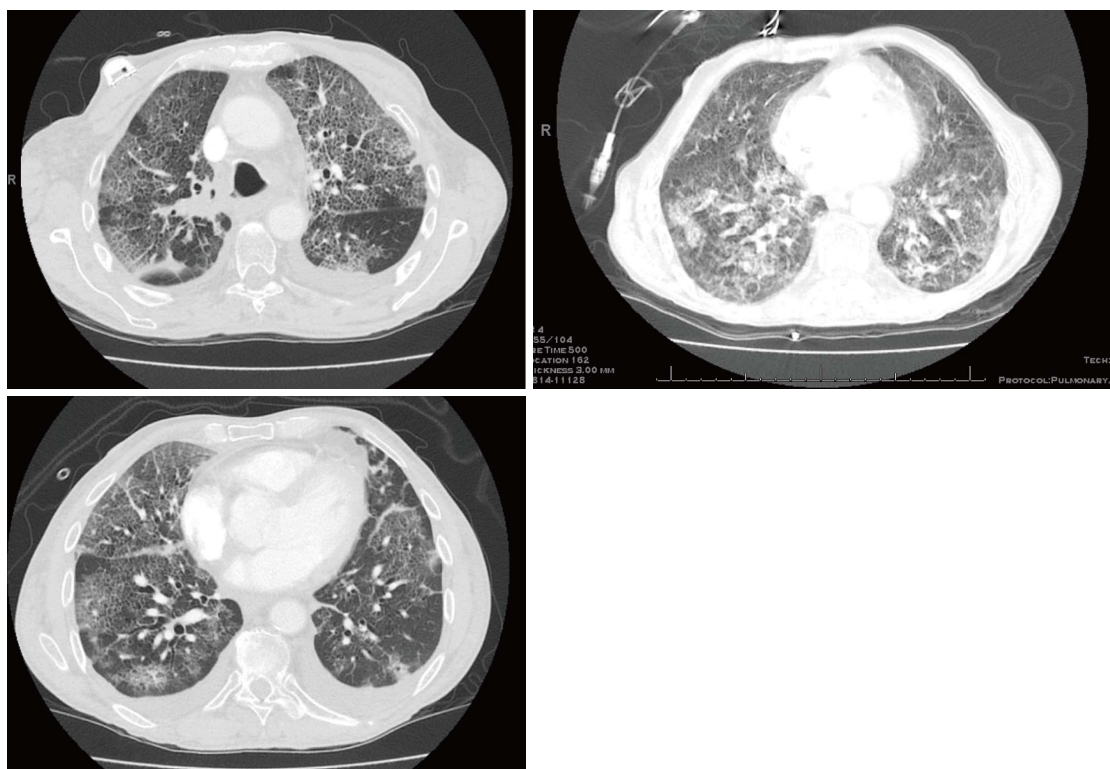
Chest computed tomography scan images demonstrating bilateral interstitial and airspace opacities.
